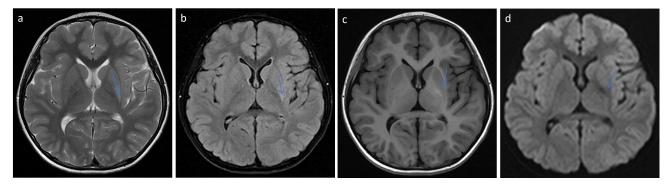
Brain MRI on July 22, 2022 (8 years and 10 months). a, T2WI; b, T2-FLAIR; c, T1WI; d, DWI. Small abnormal signal (blue arrow) in the left posterior lenticular nucleus on (d, DWI), slightly high on T2WI, T2-FLAIR, and T1WI, slightly low on DWI, with unrestricted diffusion. Compared to February 4, 2022, the area of abnormal signal in the left posterior portion of the lenticular nucleus reduced.
